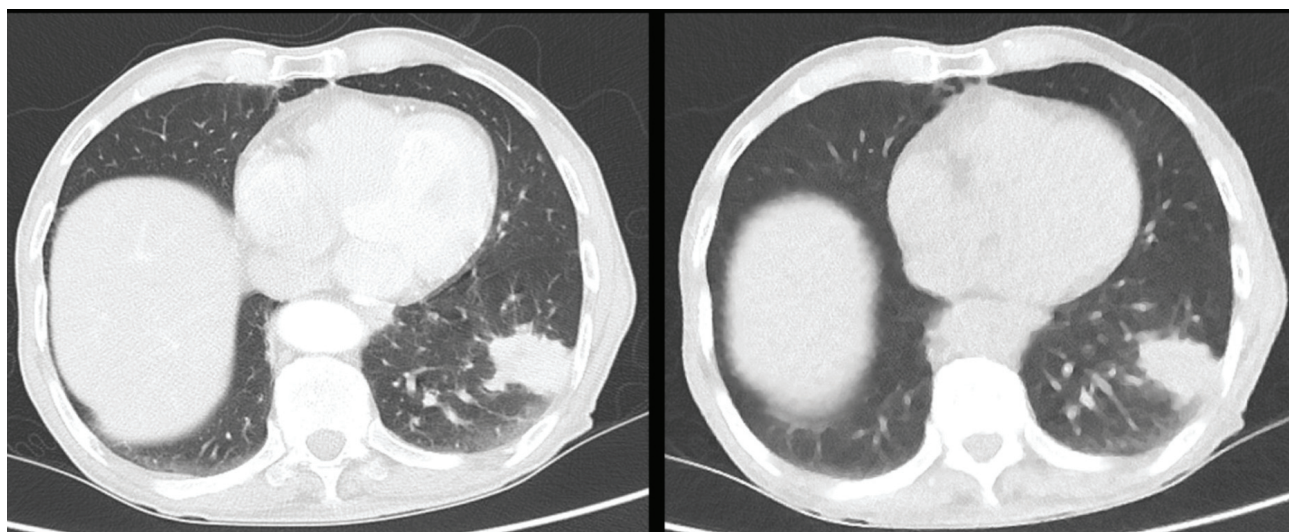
This figure shows the appearance of lung mass in (a) standard dose and (b) ultra-low dose chest CT images. CT: Computed tomography
